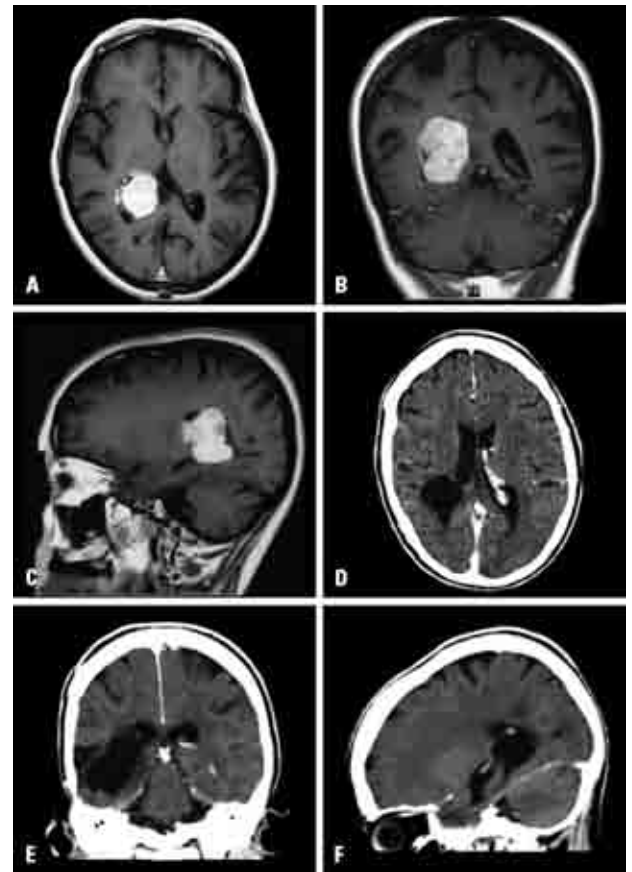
Case 5. A 63-year-old woman presenting three years history of intermittent headache and nonspecific dizziness, associated with progressive loss of visual acuity. [A B and C] Pre-operative MRI. [D, E and F] Post-operative MRI after 6 months showed no residual lesion or recurrence.
